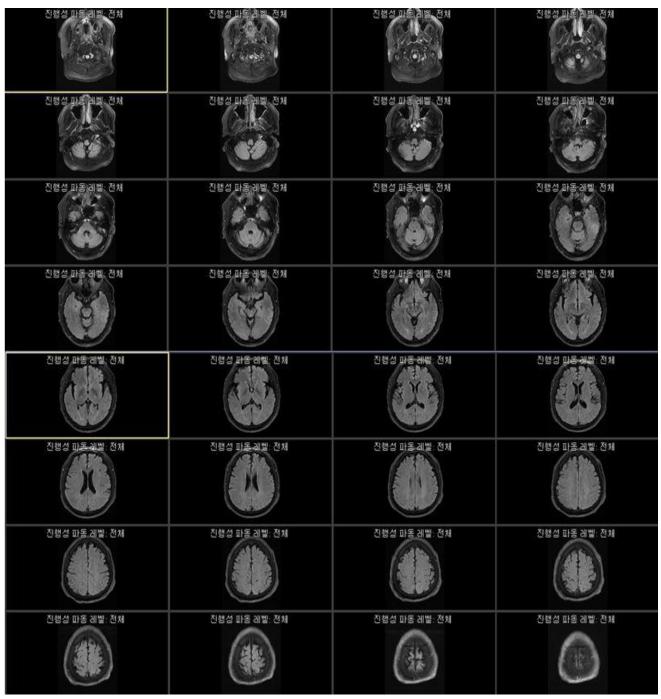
Brain MRI T2 FLAIR sequences shows no remarkable finding.
